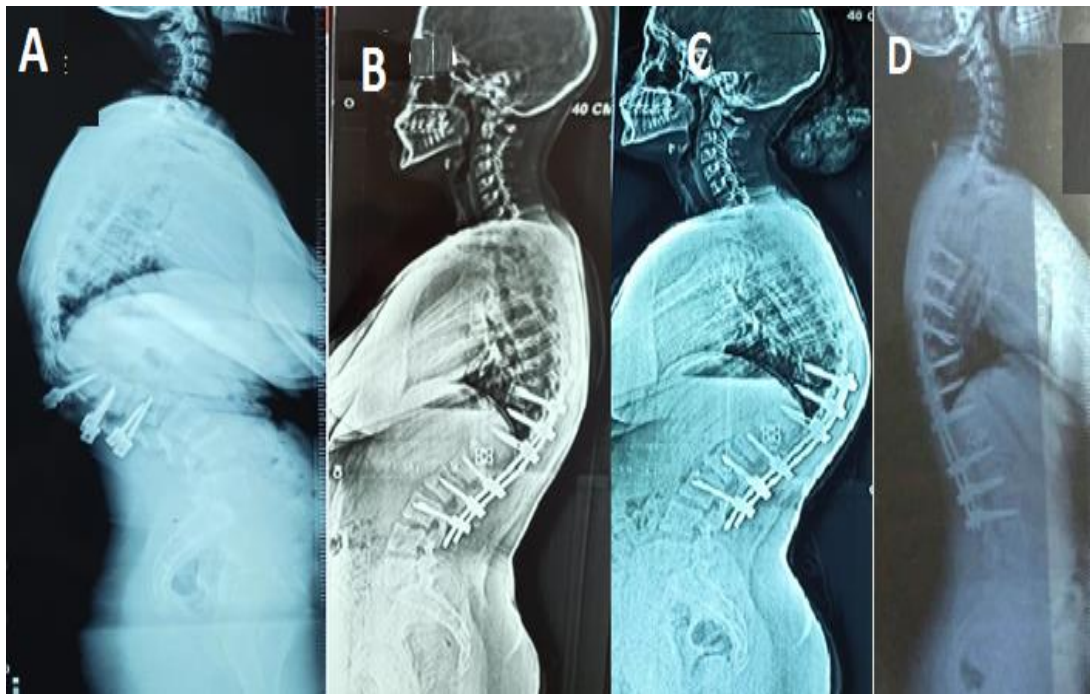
(A): longstanding X-ray 12 months after surgical fixation of L1 fracture and 6 months after rod removal due to infection at another center, (B): longstanding X-ray 1 months after the VCR (C): longstanding X-ray 6 months after the VCR showing progressive PJK, (D): Longstanding X-ray 12 months after extension of fusion.
